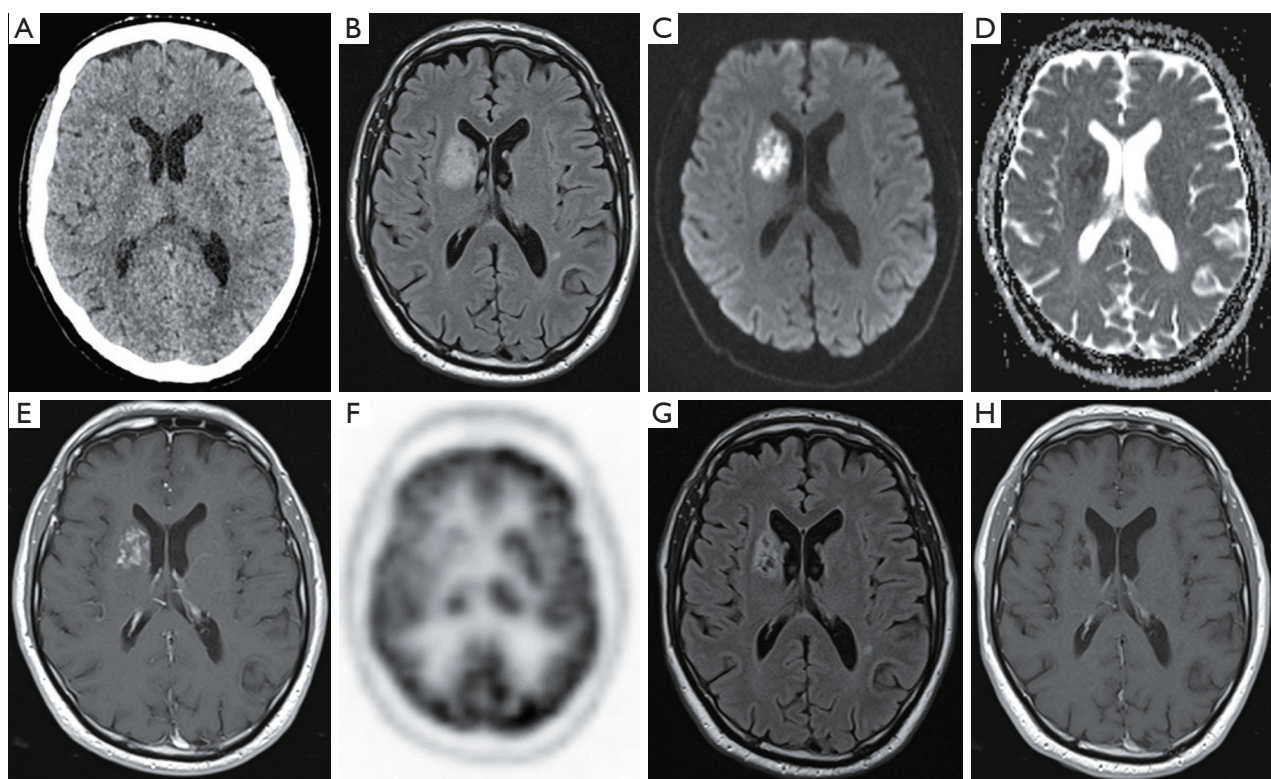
Unenhanced head CT showing small hypodensities at the right caudate nucleus head (A). Unenhanced brain MRI (B-D) demonstrating a wider right caudate nucleus lesion with high signal at Fluid-attenuated inversion recovery sequence (B) and intralésional foci of restricted diffusion (C,D). T1-weighted sequence after gadolinium-based contrast agent administration showing inhomogeneous contrast-enhancement of the lesion (E). ^{18}F -FDG PET depicting asymmetric reduction of tracer uptake of the right caudate nucleus (F). Follow-up brain MRI performed after 2 months demonstrated gliotic-malacic evolution of the lesion, without any contrast-enhancement (G,H). CT, computed tomography; MRI, magnetic resonance imaging; ^{18}F -FDG PET, ^{18}F -fluorodeoxyglucose positron emission tomography.
